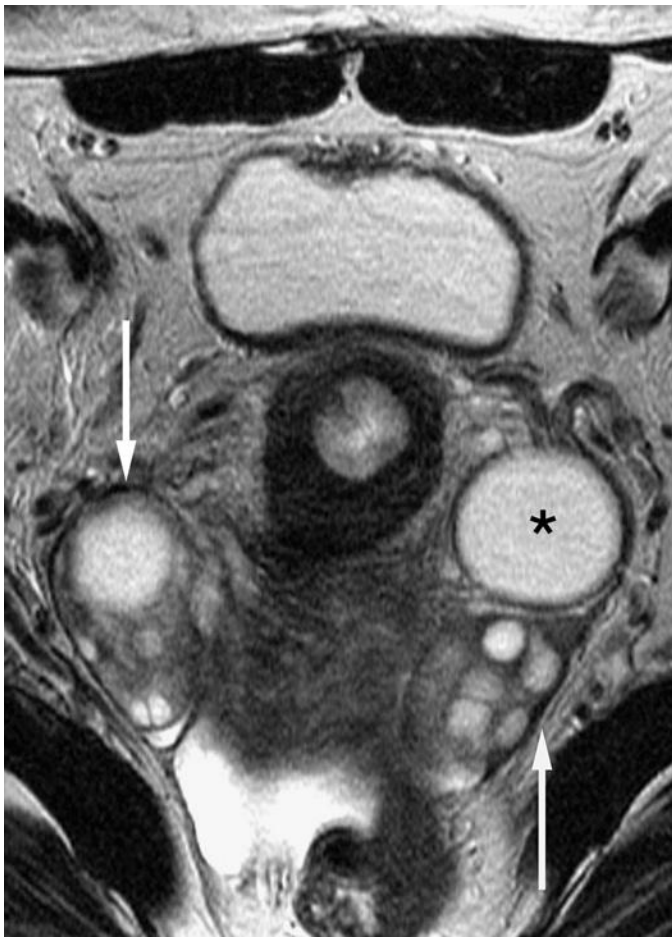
Normal ovaries. Axial T2-weighted image demonstrates the presence of multiple hyperintense follicles in both ovaries (*arrows*), one of which represents the dominant follicle (*asterisk*).
